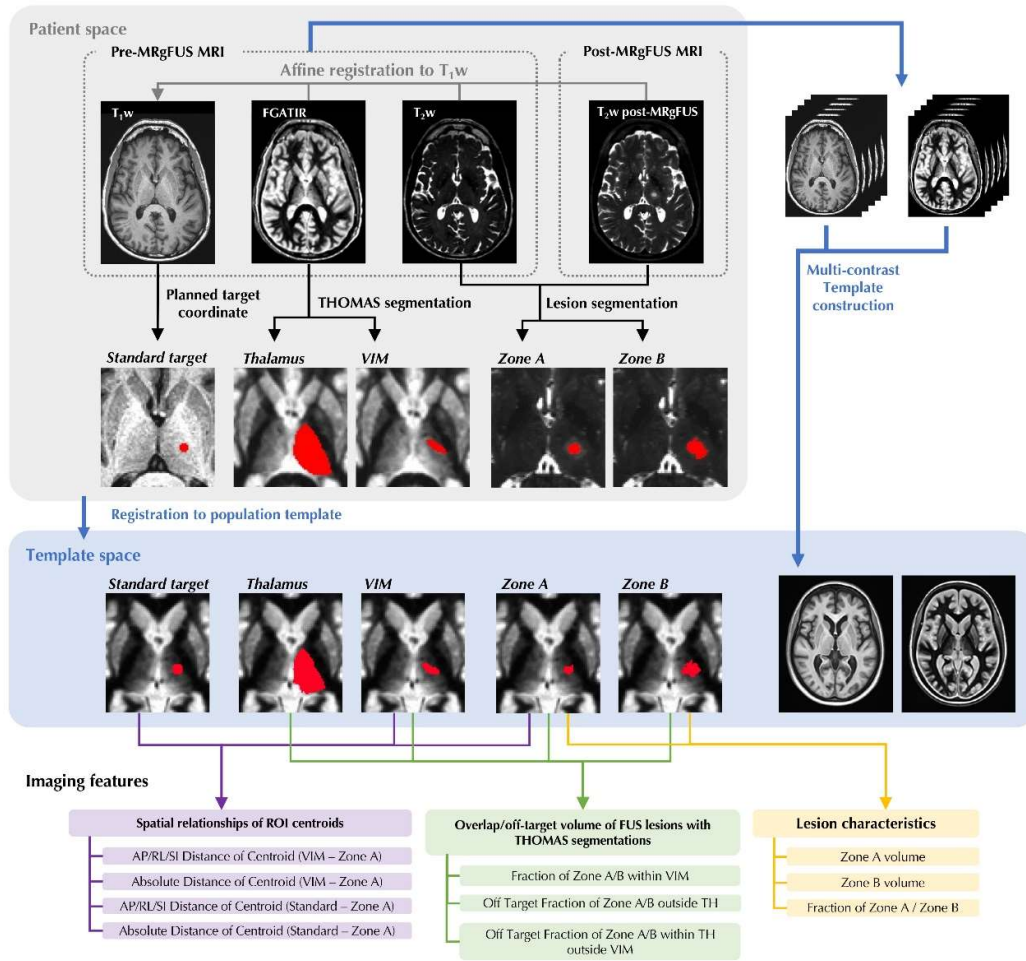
Imaging feature extraction pipeline. ROIs of standard target, FUS lesions and THOMAS segmentations were registered to the population-specific template generated from pre-operative T1-w and FGATIR images. Spatial relationships of ROI centroids, overlap of FUS lesions with segmentations and lesion volume characteristics were assessed. MRgFUS, MR-guided focused ultrasound; FGATIR, Fast Gray Matter Acquisition T1 Inversion Recovery; THOMAS, Thalamus Optimized Multi Atlas Segmentation; VIM, ventral intermediate; TH, thalamus; AP, anterior-posterior; RL, right-left, SI, superior-inferior; ROI, region of interest.
